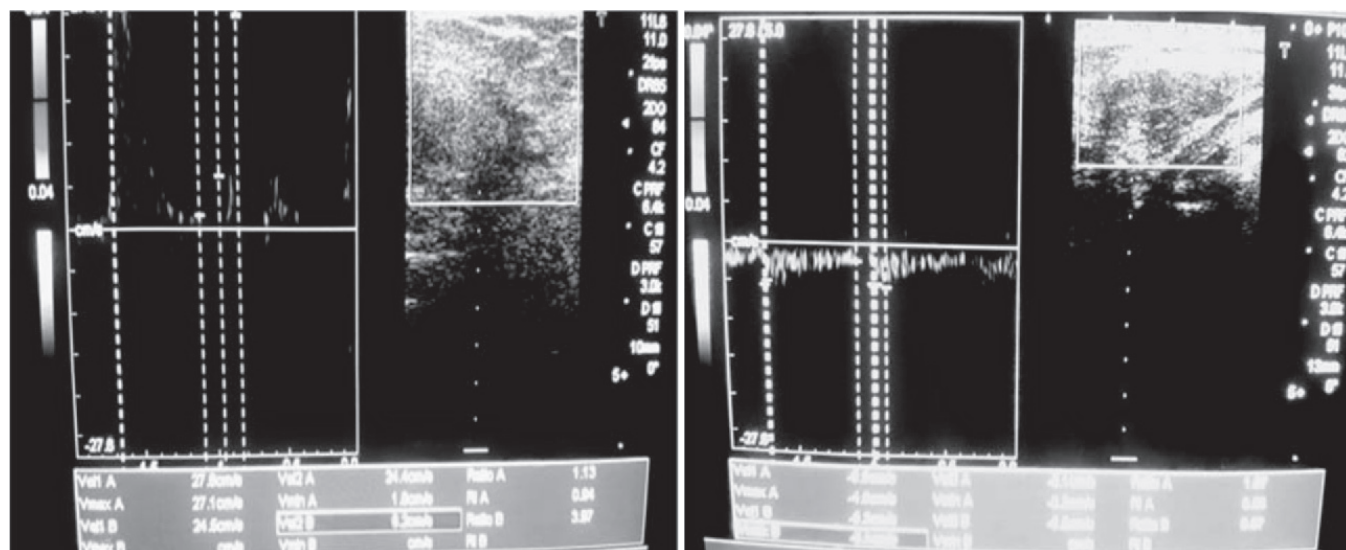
Malignant lesion with RI of 0.9 and benign lesion with RI of 0.5 on Doppler ultrasound
